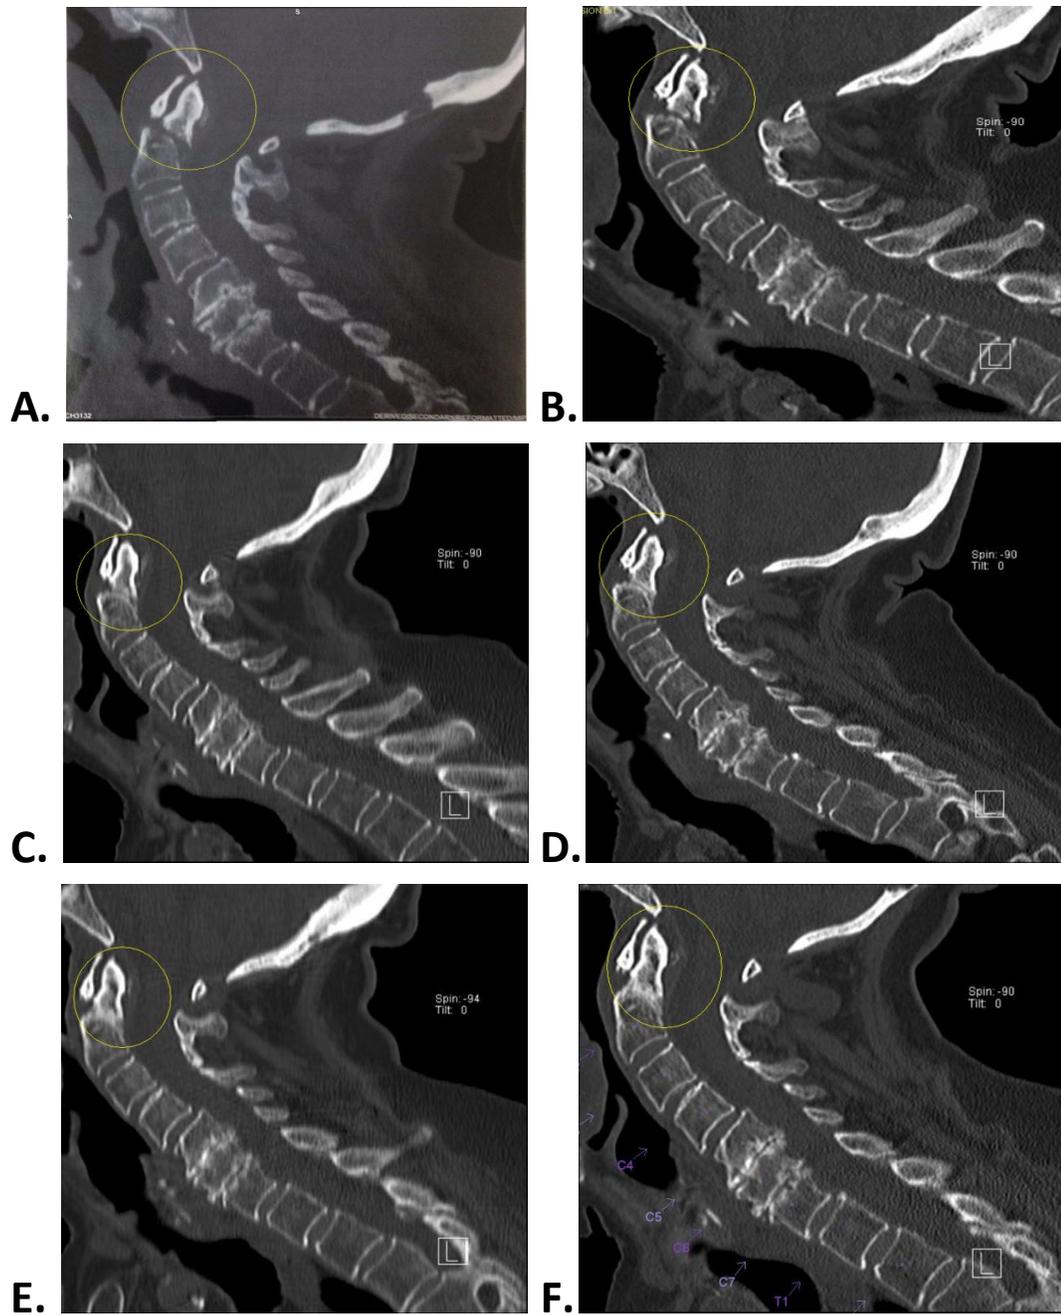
Sagittal CT images of the cervical spine at the time of the initial injury (A), and subsequent follow-up visits at 1- (B), 2- (C), 3- (D), 4- (E), and 6 months (F) show reapproximation of the odontoid to the C2 vertebral body. Healing is noted to progress from bony callus to fibrous union and finally bone growth across the fracture line. The course of treatment included four months of cervical-thoracic bracing followed by 2 months of cervical collar alone.
